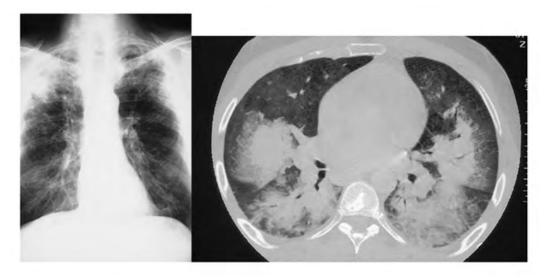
A chest X-ray revealed pulmonary infiltrates, as well as the suggestion of pleural effusion, which was confirmed by thoracic CT-scanning.
